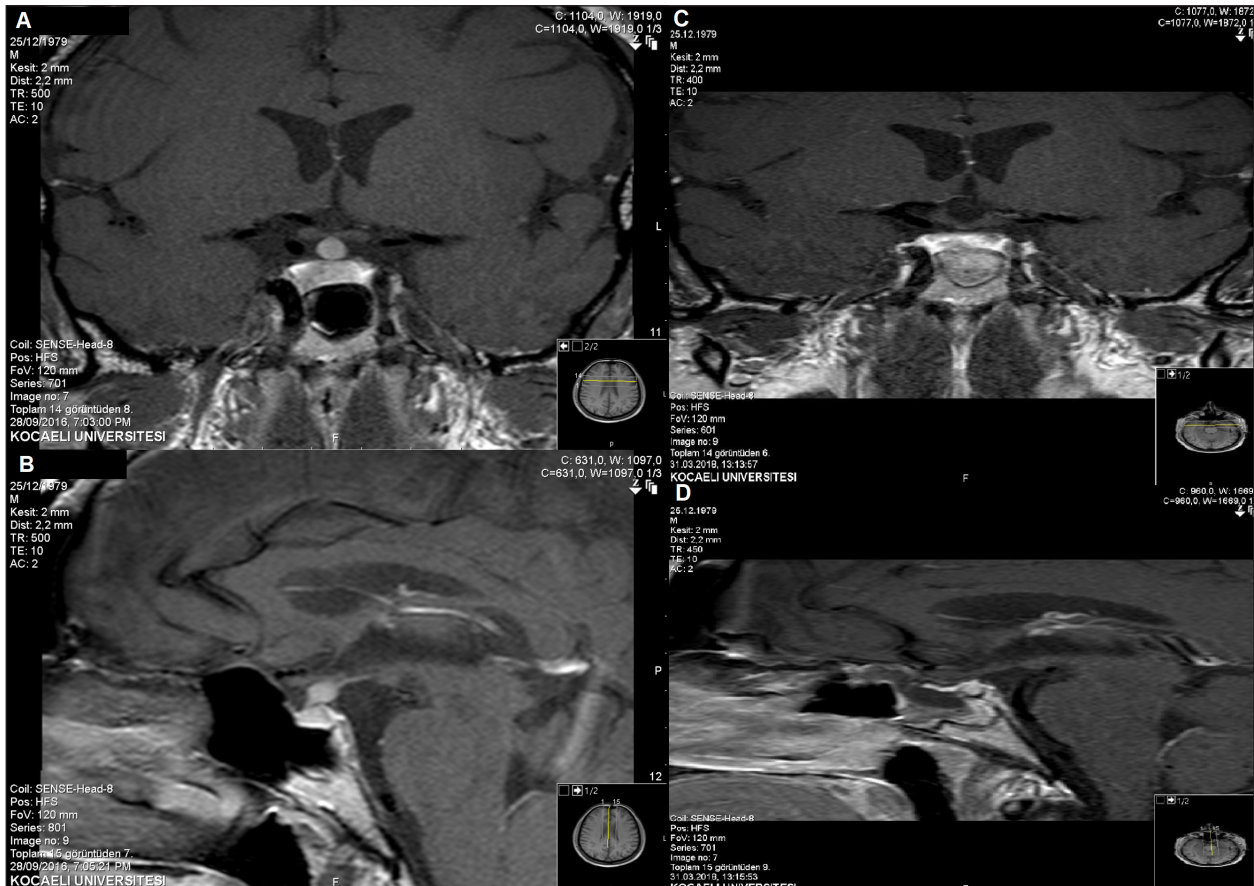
Preoperative T1-weighted gadolinium-enhanced dynamic coronal (A) and sagittal (B) MR images, single infundibular lesion measuring 6×6.5 mm. Postoperative T1-weighted gadolinium-enhanced dynamic coronal (C) and sagittal (D) MR images.
